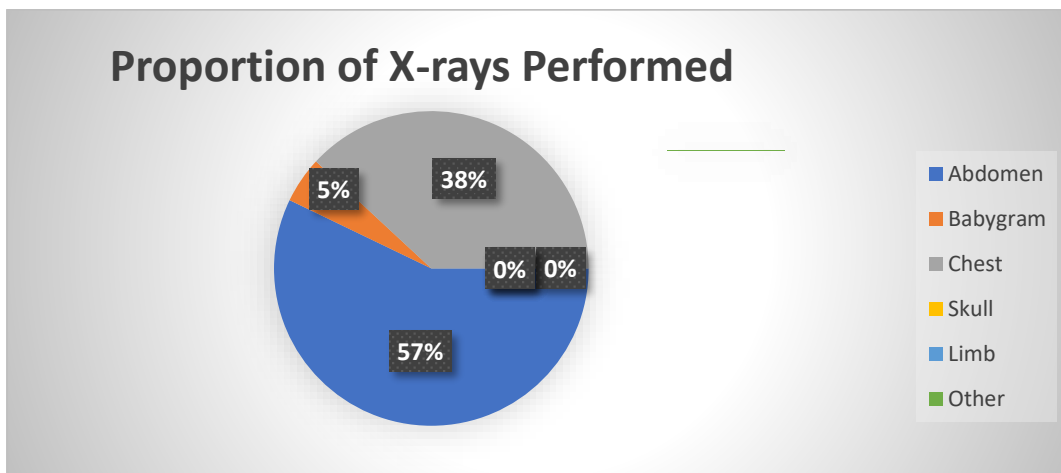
Proportion of X-rays performed
